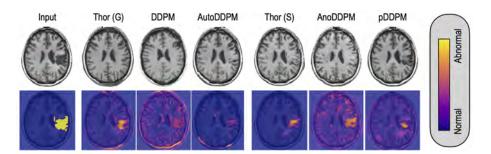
Qualitative assessment of different diffusion-based models in Brain MRI. *THOR* refines the performance of both DDPM (Gaussian) and AnoDDPM (Simplex), resulting in more accurate reconstructions and enhanced segmentations.
